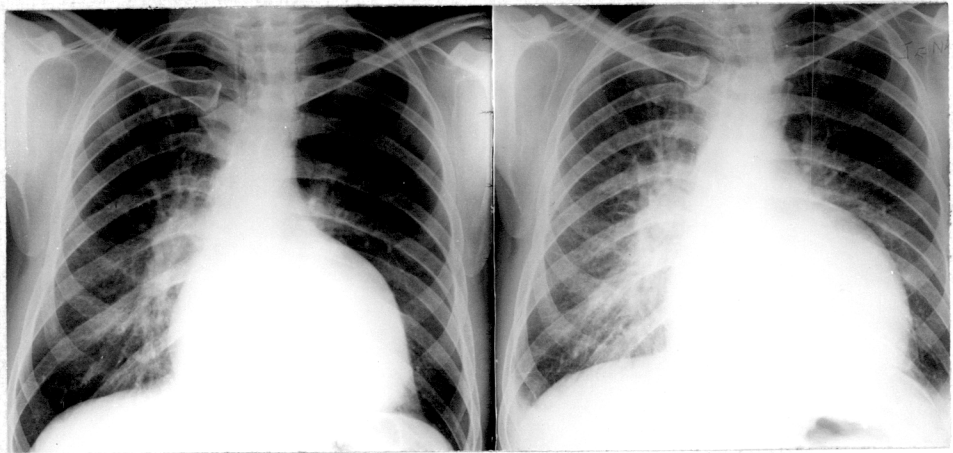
Chest radiograph of Patient number 68 (corrected transposition). The upper left border of the cardiac shadow is formed by the ascending aorta. On the left the appearance is in atrial fibrillation and on the right, in sinus rhythm. In sinus rhythm the heart is larger and pulmonary oedema is shown.
